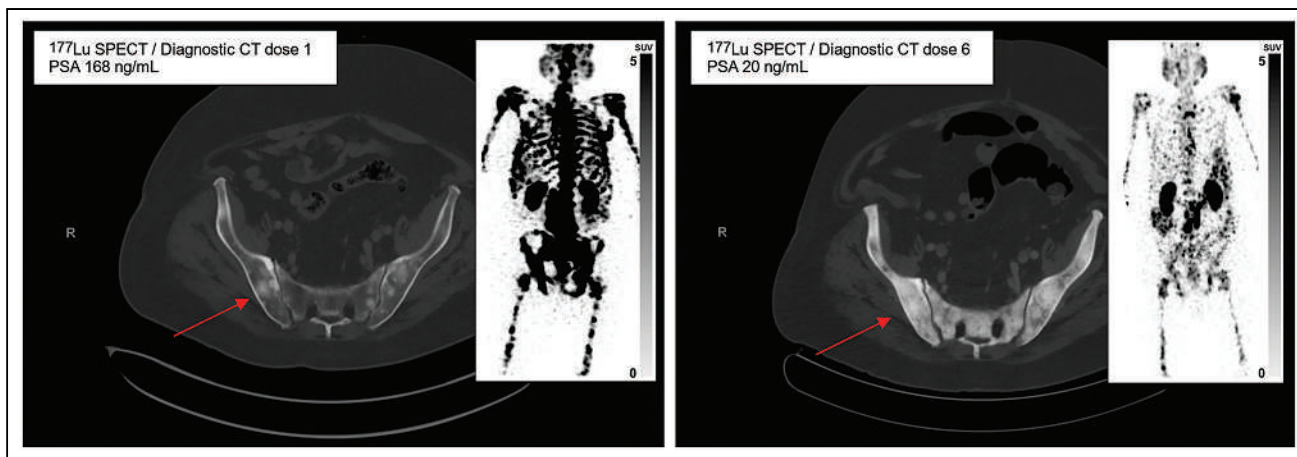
^{177}Lu -PSMA SPECT/CT images for 1 of 6 cases treated with ^{177}Lu -PSMA-I&T who developed hypocalcemia. Images within 24 h after dose 1 (left) and dose 6 (right) show significant reduction in cancer volume with concomitant marked osteosclerotic response (arrows).
